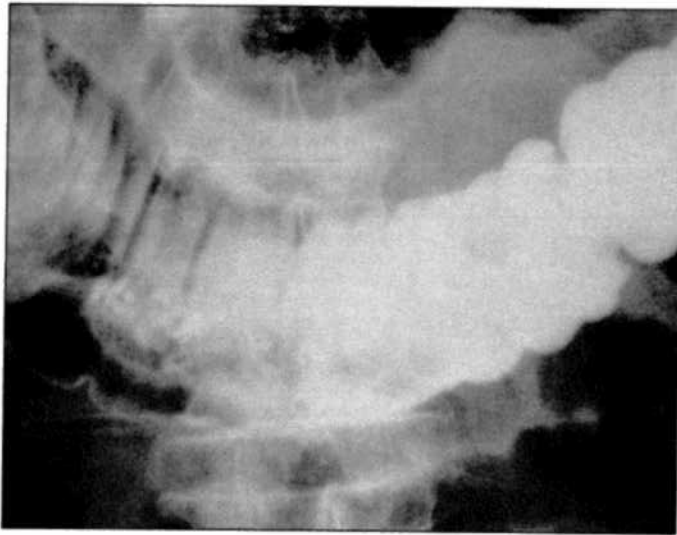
Radiograph of the transverse colon of the Fig 12 patient 24 hours later with a repeated barium enema examination shows resolution of this suspected abnormality confirming the presence of a sphincter as the original cause of narrowing.
